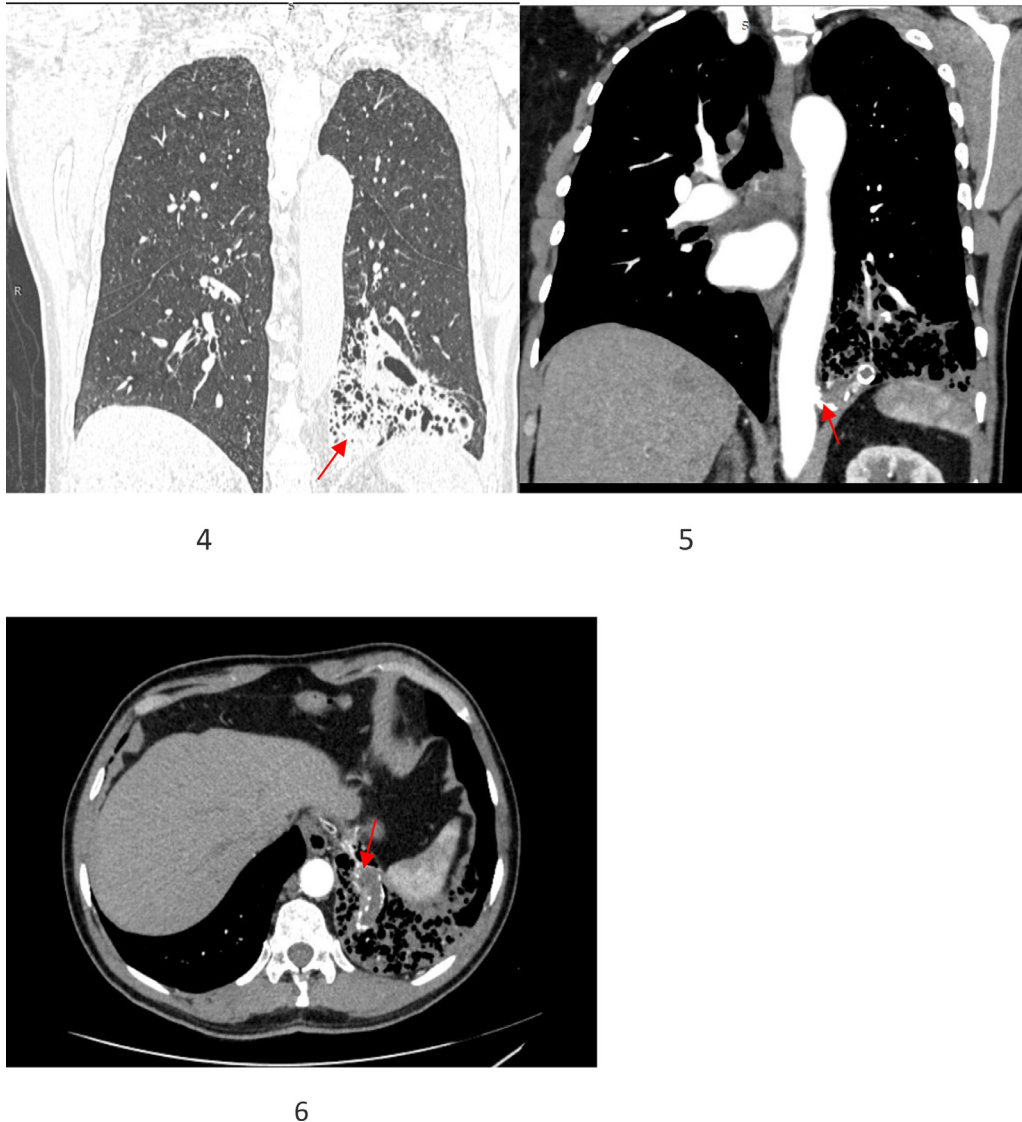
Coronal HRCT chest shows consolidation within the basal segments of the left lower lobe.
